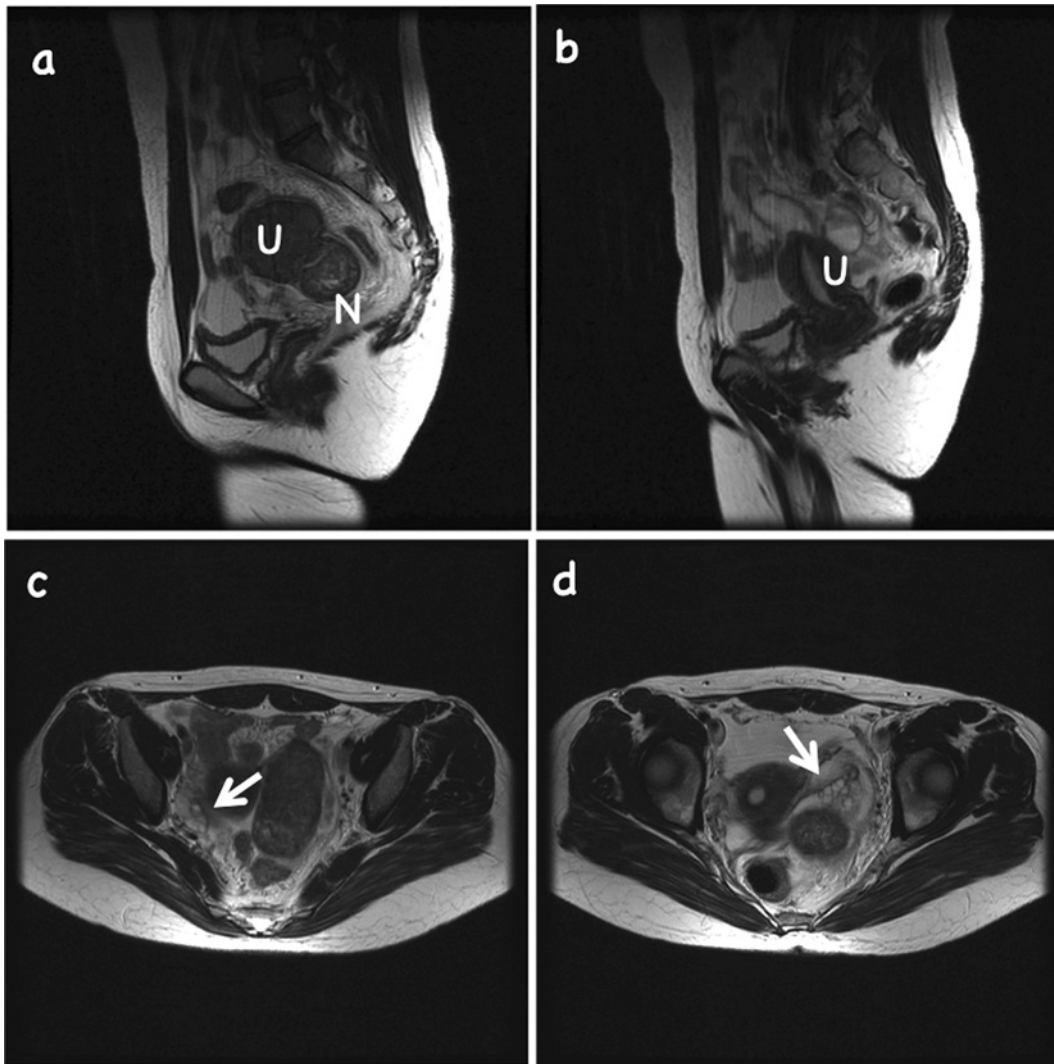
A 36-year-old female with torsion of a subserous myoma. The patient suffered from lower abdominal pain. (a,b) Sagittal and (c,d) axial T2-weighted MR images show a solid region (N) attached close to the uterine posterior wall with slightly higher signal intensity than that of the uterine corpus (U). Note the normal-appearing oval shape of bilateral ovaries (arrows). The uterine corpus (U) also appears to be normal. The pre-operative differentiated diagnosis was the acute torsion of a subserosal pedunculated node. Emergency laparotomy revealed a peduncle-like structure between the myoma node and uterus. MR, magnetic resonance.
